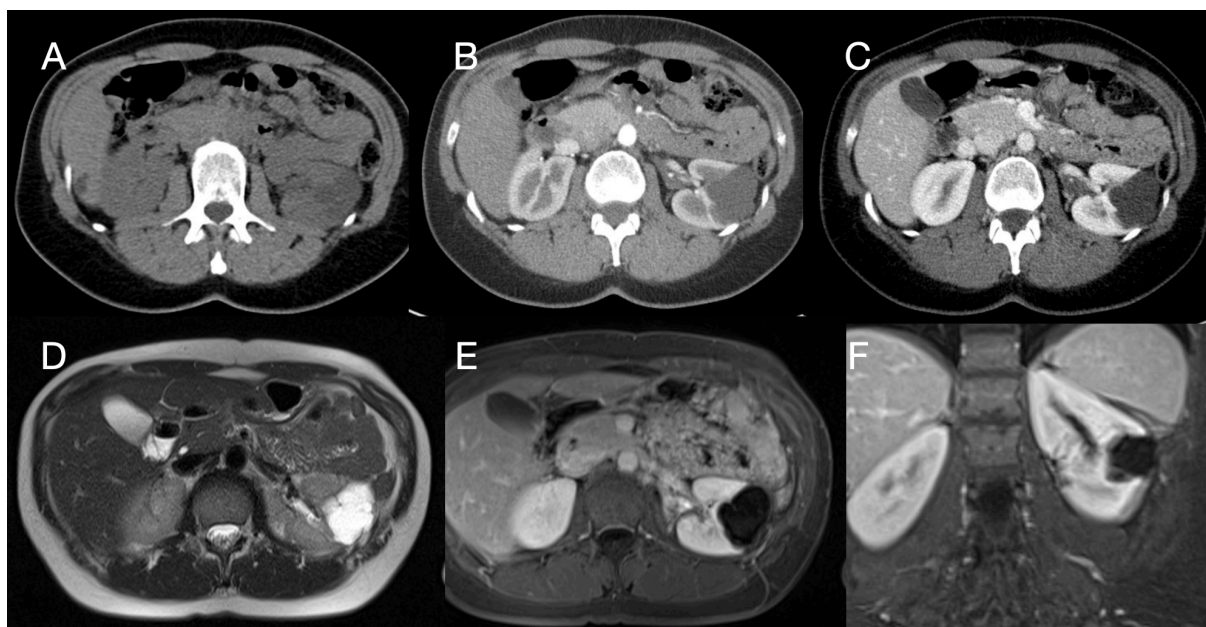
Case 1 A) CT without CM; B) CT arterial series; C) CT Venous series. In all the series there is a cystic renal mass on the left side with a hairline septa. We have evaluated the CT as Bosniak IIF D) MRI T2WI E) MRI CE T1WI axial, and F) MRI CE T1WI coronal. In T2W1 there are more than 6 septa inside the cystic mass with minimal thickened wall. After MRI examination, we upgraded the lesion to Bosniak III.
